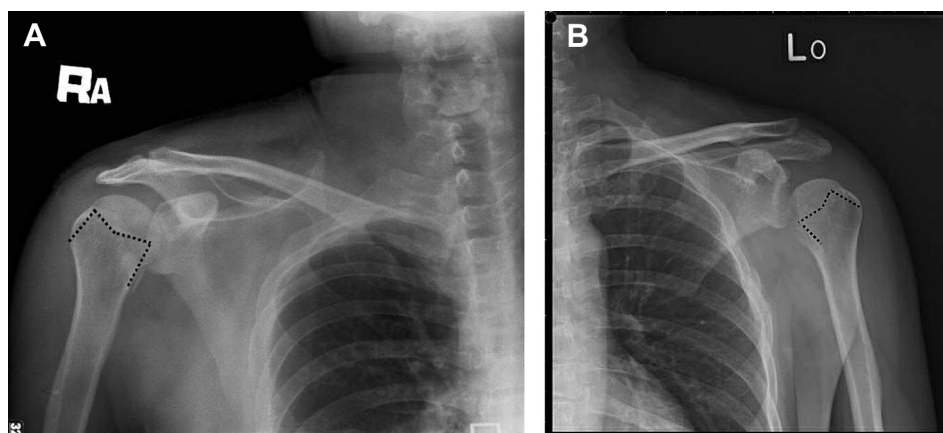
(A) Radiograph (anteroposterior view) of the right shoulder of Case 1 on arrival at the emergency room showing a fracture of the lesser tuberosity. (B) Radiograph (anteroposterior view) of the left shoulder of Case 2. The projections of the greater and lesser tuberosity borders form the letter “M”. The Mouzopoulos sign is positive in both cases.
